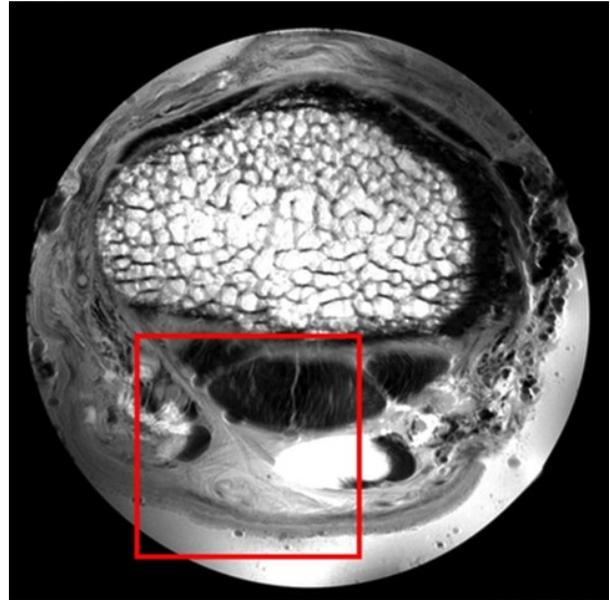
b. HR-MRI, proximally of level C. Frame shows region of interest.
